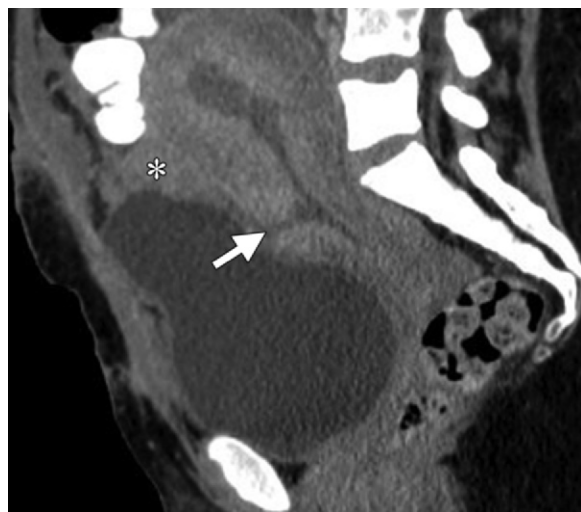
Normal postoperative appearance of a cesarean delivery incision at CT. (a) Axial contrast material-enhanced CT scan through the pelvis obtained in a 35-year-old woman demonstrates an oval area of low attenuation (\*) at the site of the low transverse incision in the anterior lower uterine segment. (b) Sagittal reformatted CT image more clearly shows a combination of edema (\*) and a small hematoma (arrowhead) at the incision site.
